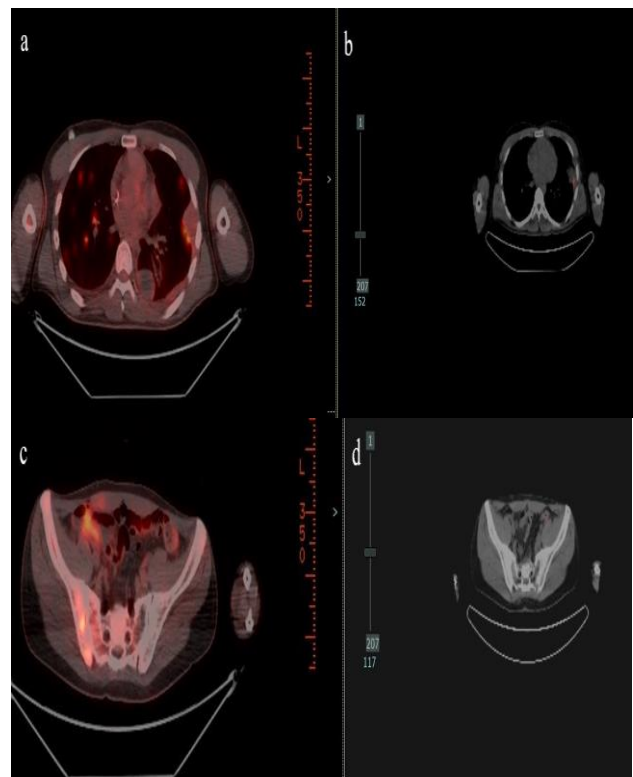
(A-D): PET CT of FDG avid multiple lung nodules prior to VIT chemotherapy. PET CT of resolution of FDG avid lung nodules after VIT chemotherapy. PET CT of FDG avid tumor in the hemipelvis prior to VIT chemotherapy and PET CT of resolution of FDG avid tumor in the hemipelvis after VIT chemotherapy.
